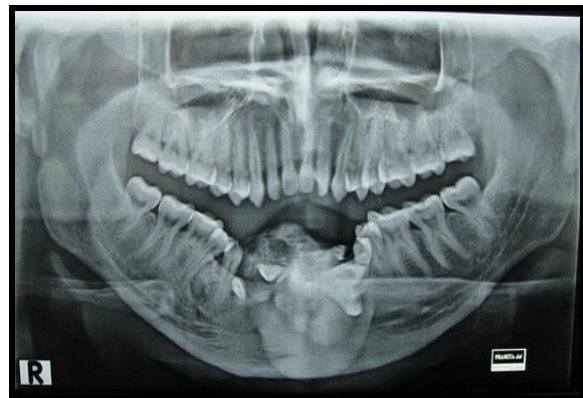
Panoramic X-ray showed the lesions had entered the mature stage showing entirely radiopaque lesion surrounded by radiolucent border
